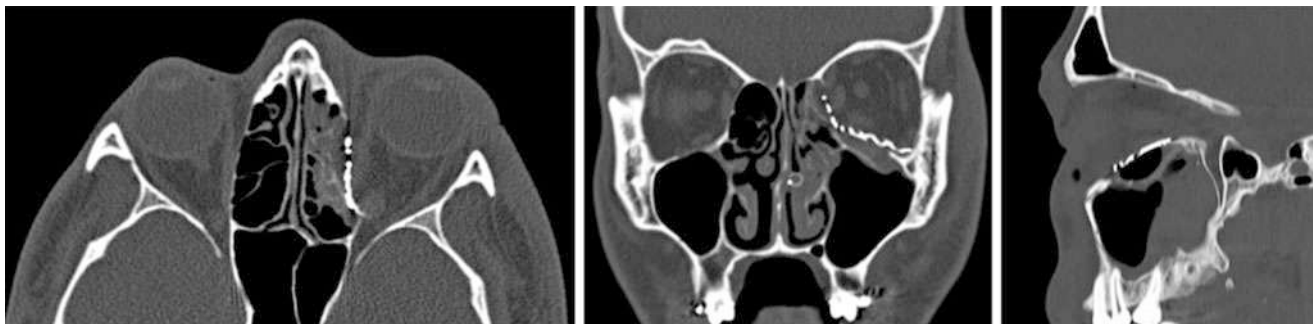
Axial, coronal and sagittal bone window postoperative CT Scan: Ideally placed prebent (AIOS) prefabricated anatomic titanium plate for combined left orbital floor-medial wall fracture. Note reconstruction of the inferomedial orbital strut, with posterior convexity with implant resting against the posterior ledge restoring symmetry with the contralateral orbit
